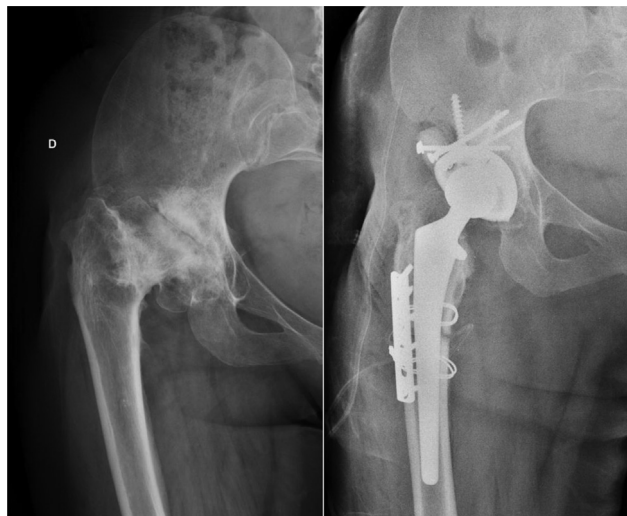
Preoperative (left) and immediate postoperative (right) anterior-posterior radiographs, showing bone graft impacted in the acetabular roof and shortening osteotomy at the subtrochanteric region.
